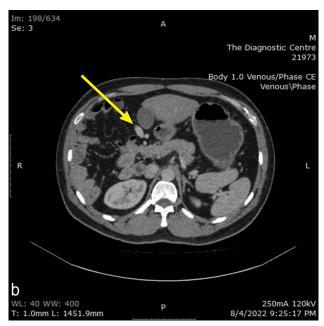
Axial images (3a, 3b) of IV contrast-enhanced abdominopelvic CT demonstrates splenules along with a parent spleen (yellow circle in 3a). Preduodenal portal vein variant also appreciated, taking an anomalous extra capsular route anterior to both the duodenum and head of pancreas (yellow arrows in 3a, 3b).
